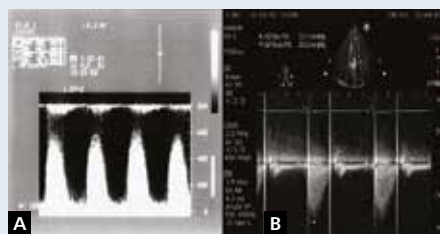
Transthoracic echocardiogram supra-sternal view (A) before cardiac surgery revealed a significant aortic transvalvular gradient and apical five-chamber echocardiogram with colour and CW Doppler (B) after 15 years showed moderate aortic transvalvular gradient with small paravalvular aortic leak
